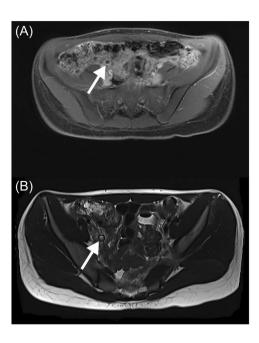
MRI Image demonstrating acute appendicitis. The (A) axial T1-weighted and (B) axial T2-weighted images reveal a dilated, fluid-filled appendix (outlined by arrow) with thickened and enhancing walls, consistent with acute appendicitis. MRI, magnetic resonance imaging.
